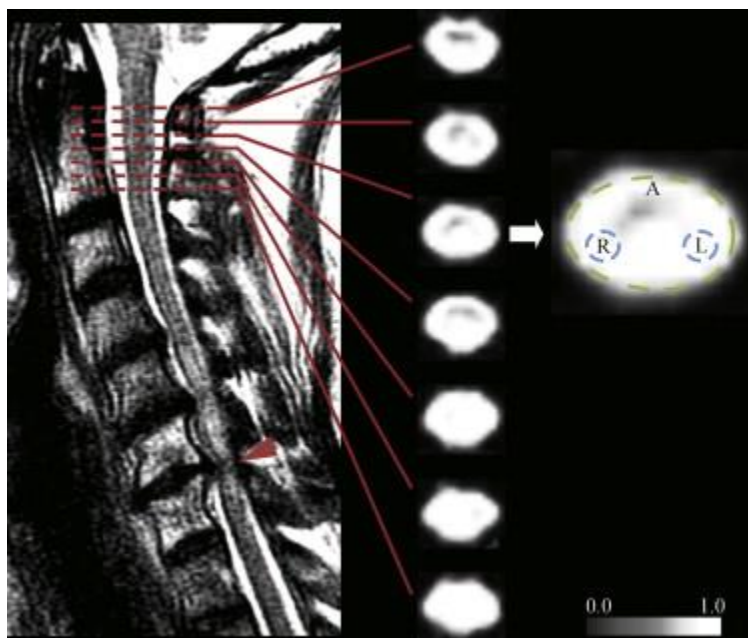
Sagittal cervical spine T2-weighted image of subject 8 showing 7 axial fractional anisotropy maps through the high cervical cord (red dotted line). *Solid arrowhead* shows the injury site at the C6-7 intervertebral disc level. A single fractional anisotropy map is magnified to show the whole cord regions of interest (*green*) and the regions of interest for the corticospinal tracts (*blue*). A, anterior; R, right; L, left.
